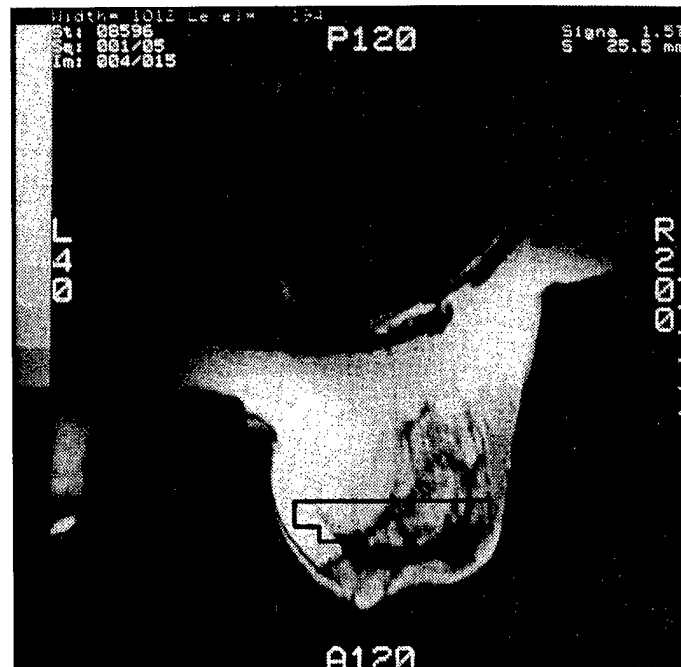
MRI (cranio-caudal direction) of case 3, post-lumpectomy. The closed area shows the area in which optical imaging was conducted (see Figure 9).
